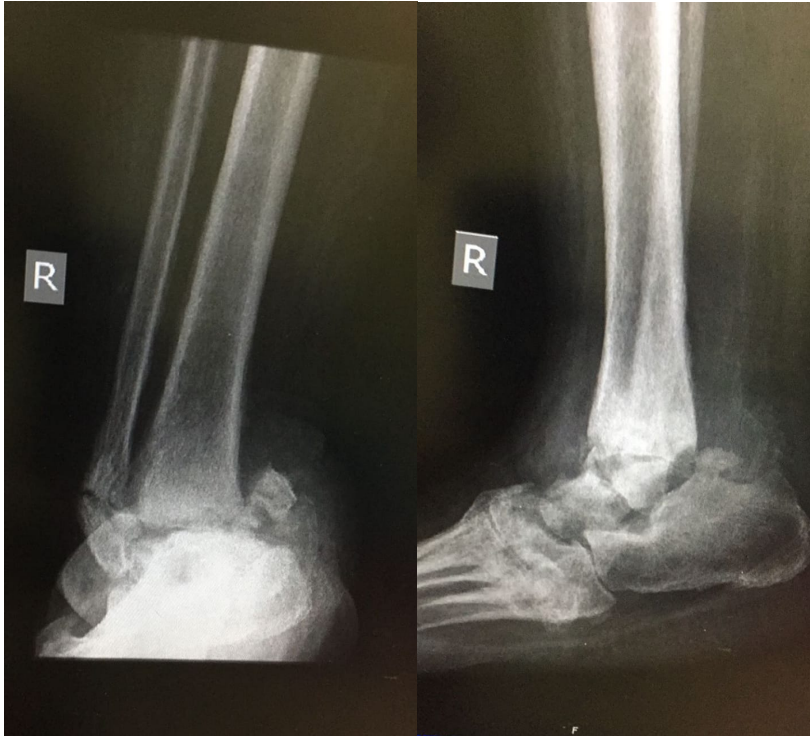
showing weight bearing xrays of foot with midfoot and hindfoot charcotsarthropathy in consolidated phase. Note also there is loss of Mearys angle on lateral view.
